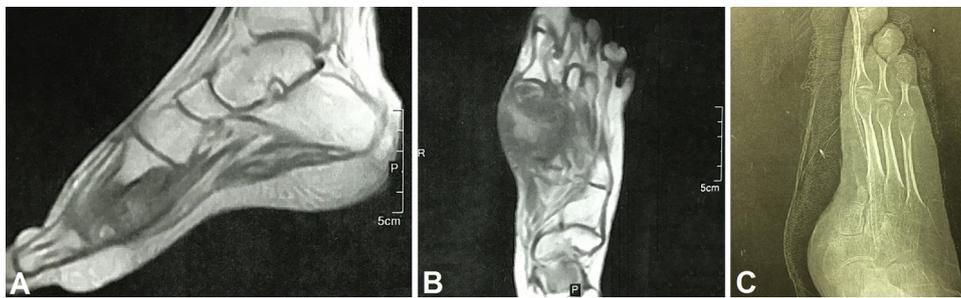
A case of female patient 16 years old with Ewing's sarcoma of the forefoot. A) Preoperative MRI, sagittal view. B) Preoperative MRI, coronal view. C) Two-months postoperative X-ray after resection of the tumor with the medial 2 rays showing no recurrence.
